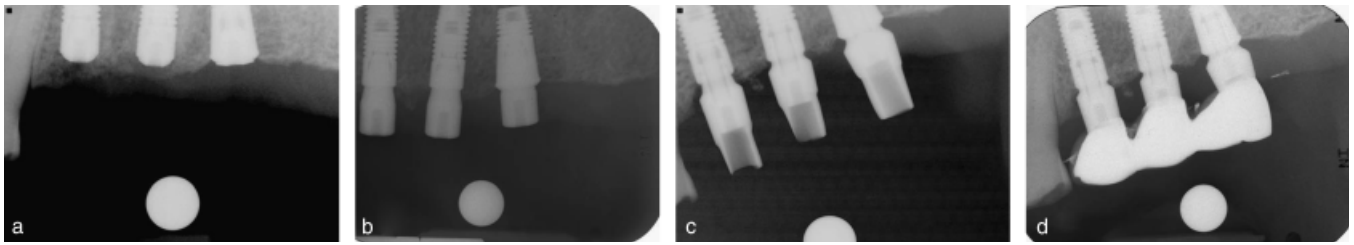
Intra-oral radiographs of implants. (a) First surgery; (b) second surgery; (c) prosthesis delivery; (d) 1-year follow-up.
